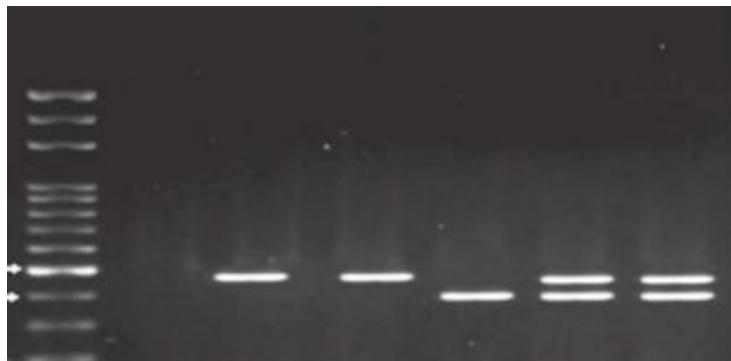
RFLP Product Analysis Using The SphI Enzyme for Mmp9 Gene Polymorphism (CC: 385 bp, CT: 317, 385 bp, and TT: 317 bp)
